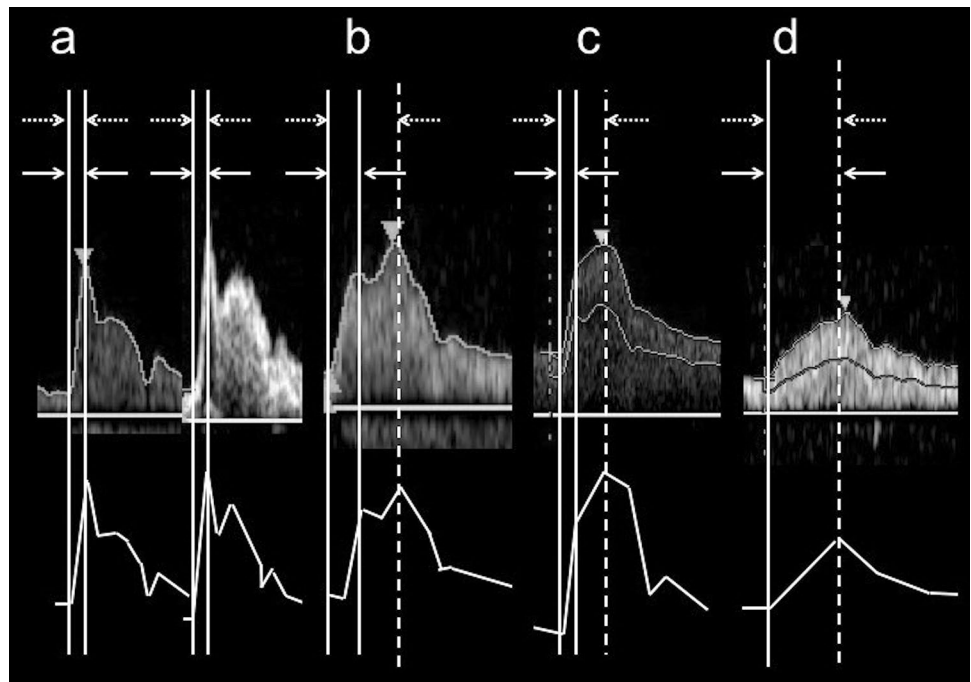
Pulse Doppler waveform changes distal to the stenosis. When the stenosis is moderate or severe, the pulse Doppler waveform distal to the stenosis shows a turbulent flow (a) and prolonged acceleration time (b)
